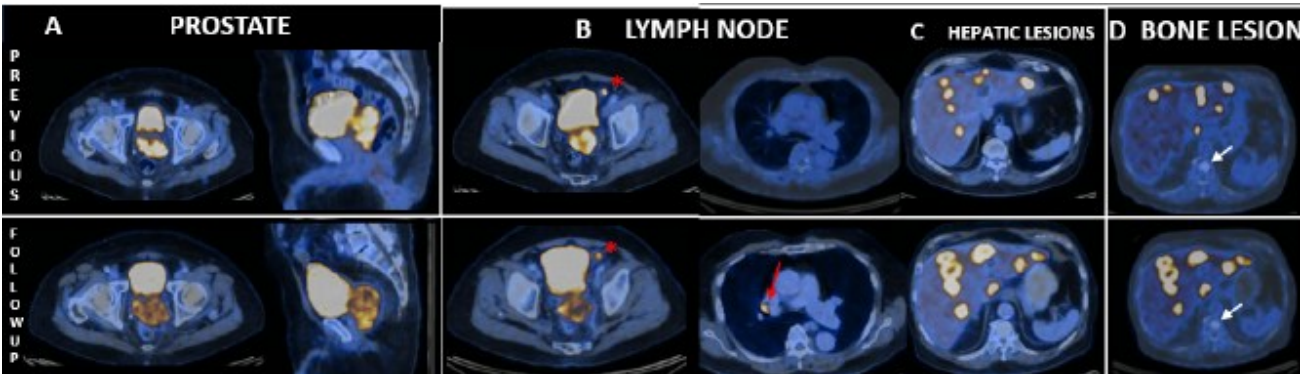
Comparison of fused serial F-18 FDG PET/CT with 7-month intervals after 6 cycles of chemotherapy.
